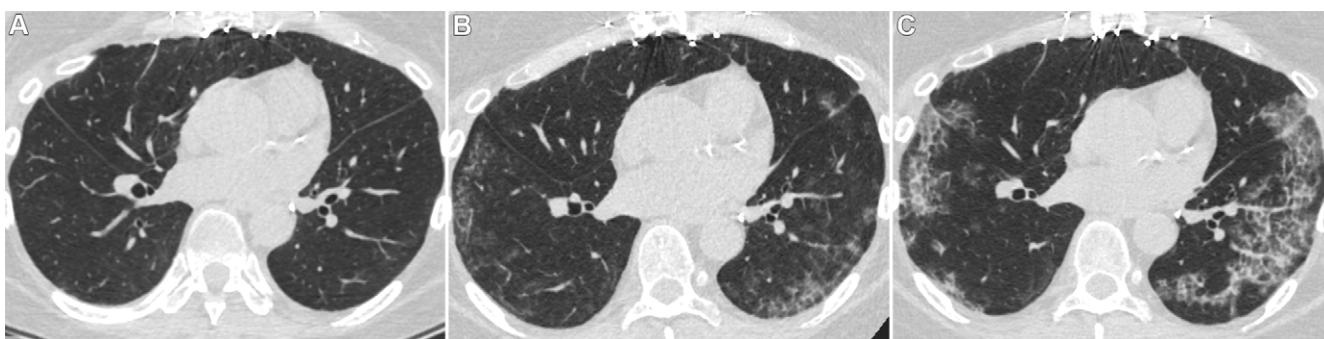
Images in a 55-year-old woman with pulmonary alveolar proteinosis recurrence. Axial CT lung window images at (A) 2 months, (B) 1 year, and (C) 2 years after lung transplantation show increasing patchy ground-glass opacities and septal thickening (crazy paving) compatible with recurrence of pulmonary alveolar proteinosis.
